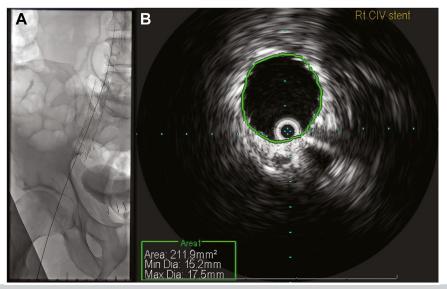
(A) Fluoroscopic image of a fully-expanded right common iliac vein (*CIV*) stent extending into the external iliac vein (*EIV*). (B) Intravascular ultrasound (*IVUS*) image of the right CIV after Venovo 16×80 mm self-expanding stent placement (C.R. Bard, Murray Hill, NJ).
